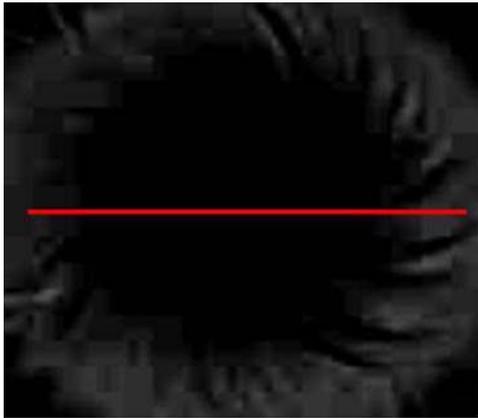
2D Image of CT Reconstructed Slice of Pre irradiated gel.
